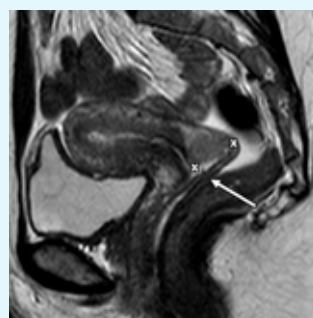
Sagittal T2-w MRI scan in a 34-year-old woman showing a 3cm tumour (between callipers) abutting the posterior vaginal fornix (arrow) consistent with Stage IB2 disease.
